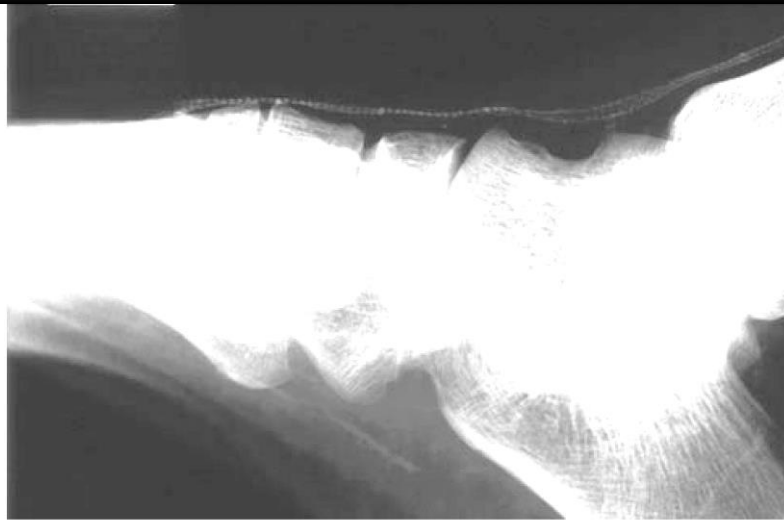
Lateral foot x-ray shows complete stent collapse in the dorsalis pedis artery. The collapsed stent could not be recanalized, and the patient had to undergo a major amputation
